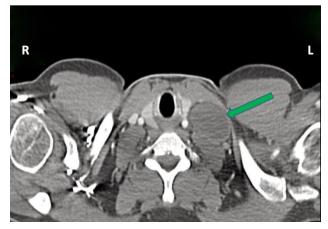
CT scan showing left neck lymphadenopathy (green arrow).
